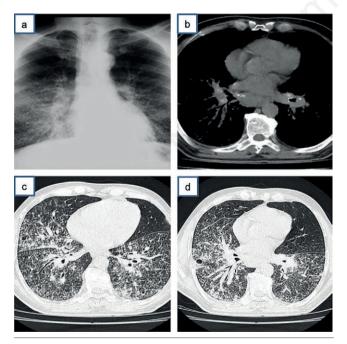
a) Chest X-ray June 2021, with multiple bibasal pulmonary nodules. b) CT sca in mediastinum window showing calcified hilar and mediastinal lymph nodes. c and d) CT scan in the pulmonary window with multiple centrilobular micronodules, which converge in some areas, with a tendency to consolidate, and some small pulmonary cysts.
